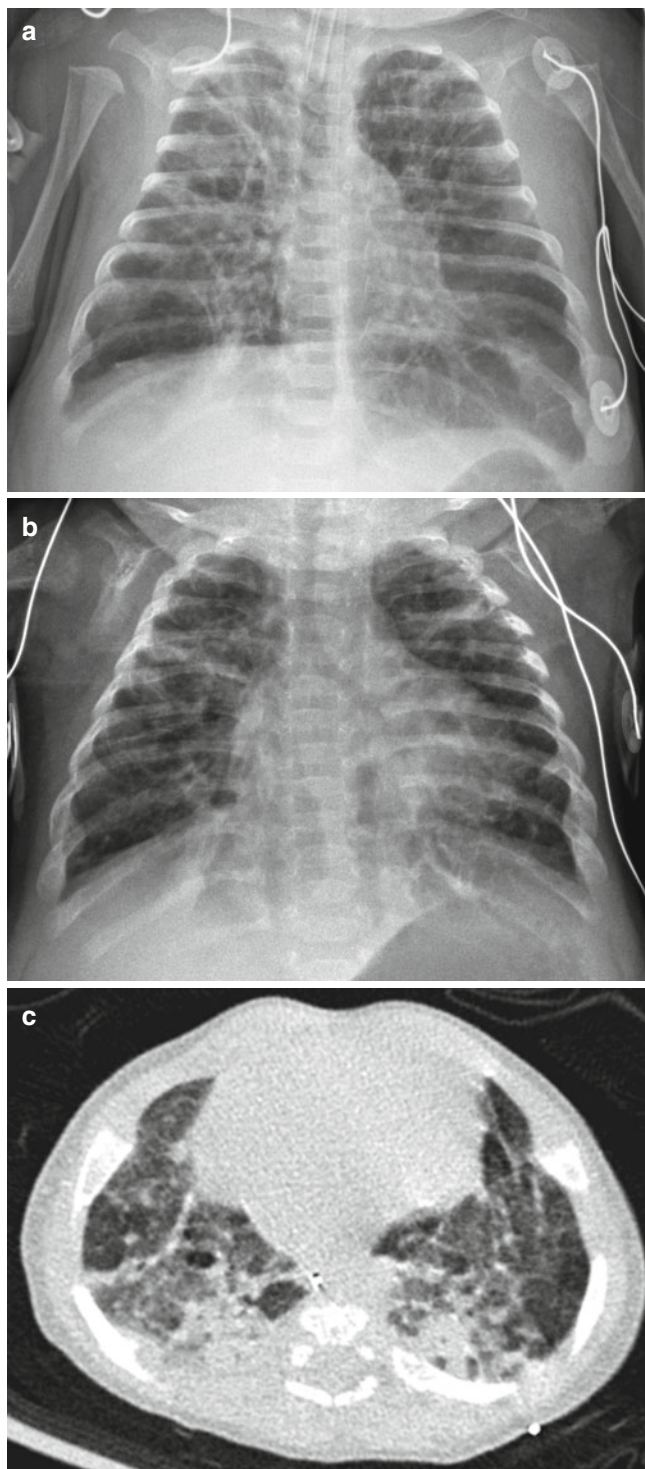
Classic severe bronchopulmonary dysplasia (BPD). (a) Anteroposterior chest radiograph obtained in a preterm infant at 37 weeks' postmenstrual age shows hyperinflated lungs with alternating areas of lucencies and strand-like coarse opacities. (b, c) Chest radiograph (b) and CT (c) in a 4-month-old infant born at a gestational age of 27 weeks. Chest radiograph reveals diffuse coarse irregular opacities and alternating areas of hyperinflation. Axial CT scan demonstrates lucent areas of variable size, multifocal atelectasis, coarse interstitial lines of fibrosis, and architectural distortion. Bronchiectasis does not occur
